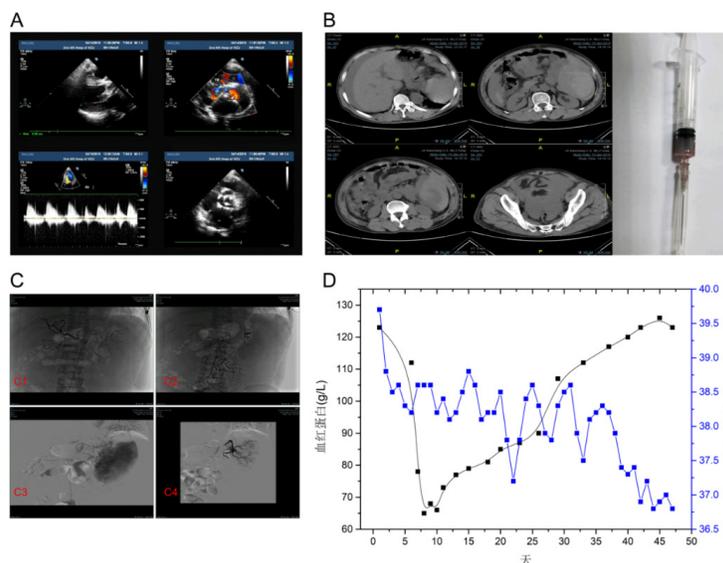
A: No obvious neoplasms were observed in the color Doppler ultrasound. B: Abdominal CT and diagnostic abdominal puncture suggest hemorrhaging in the abdominal cavity. C: c1: no contrast medium extravasation in hepatic arteriography; c2: no significant contrast medium extravasation in superior mesenteric arteriography; c3: contrast agent extravasation in splenic arteriography; c4: no contrast extravasation after inferior splenic artery embolization. D: Changes in the highest body temperature, hemoglobin, and mean radial arterial systolic blood pressure during patient treatment.
